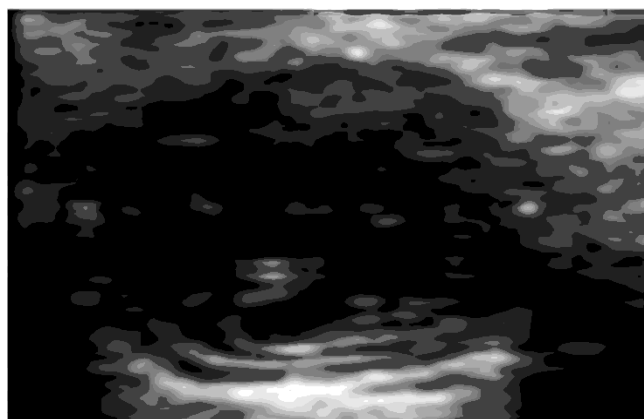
Sonogram. Echinococcal cyst type CE4
